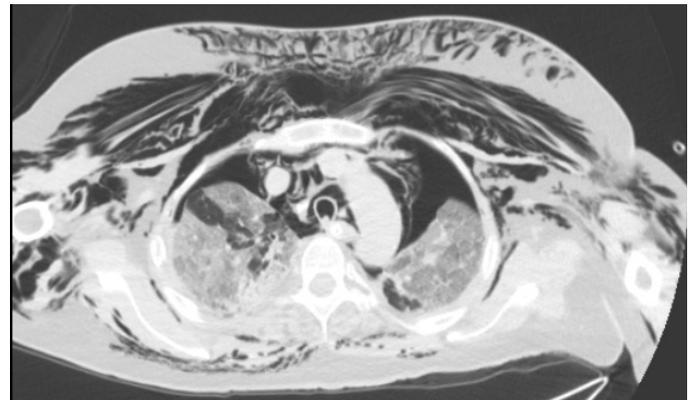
Pneumomediastinum and pneumothorax in thorax CT.
